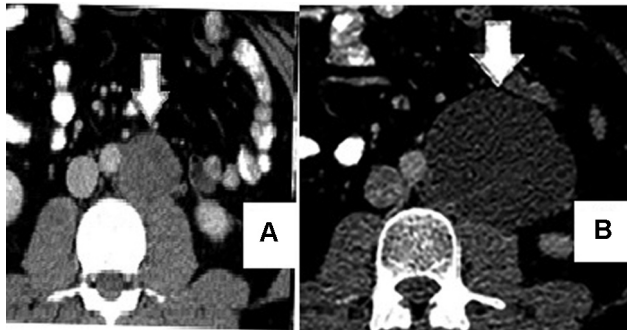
Prechemotherapy axial contrast-enhanced computed tomography (CECT) scan of mid abdomen (A) showing a left paraaortic nodal mass that is predominantly solid with central necrosis. Postchemotherapy CECT scan (B) at the same level showing significant increase in the size of the left paraaortic mass, currently with a predominant cystic appearance and thin internal septations.
